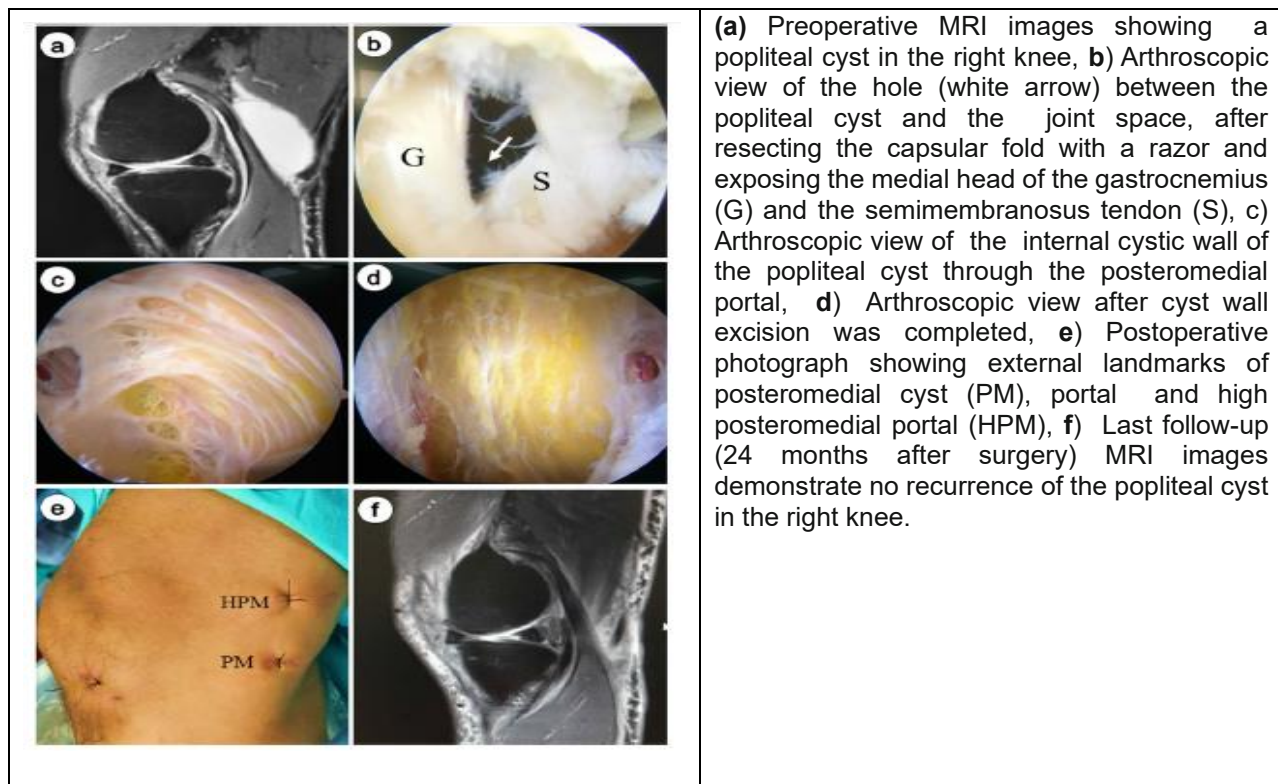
Preoperative MRI images showing a popliteal cyst in the right knee.
